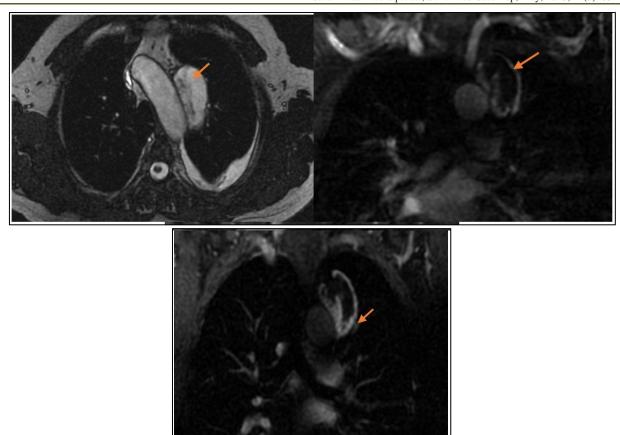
A high signal T2 mass, rapidly enhancing in the post contrast scan, showing the same enhancement pattern found on the CT scan (Yellow arrow)
